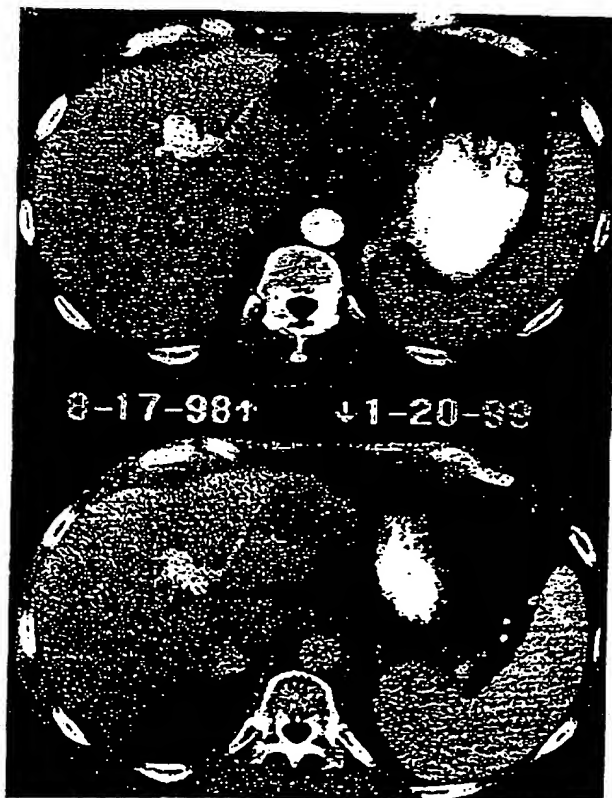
Computed tomography scans of the abdomen before (top) and after (bottom) 5 months of treatment with thalidomide. The bottom scan shows shrinkage of the tumors in the left and right lobes of the liver.
